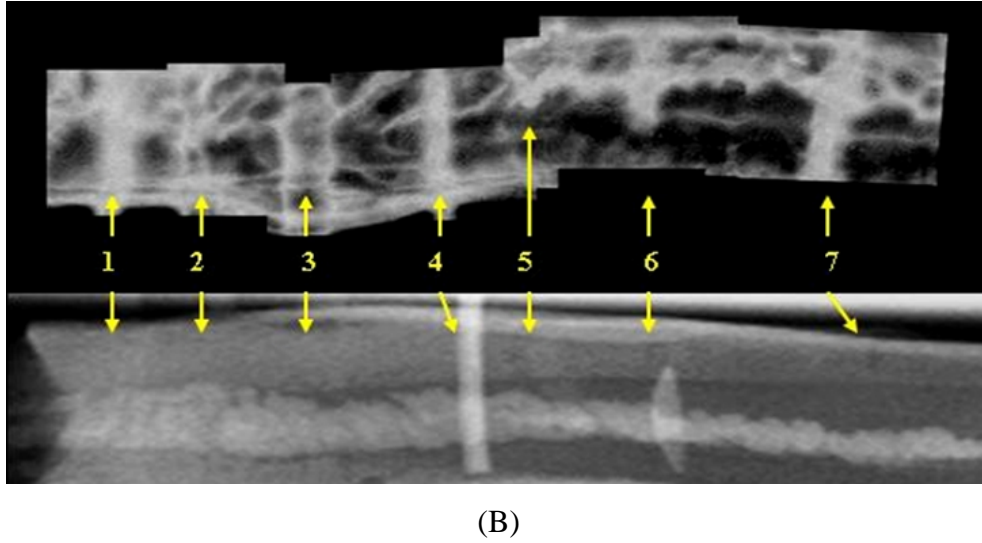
Displays of the inverted C-scan image with film-based radiograph and CR image: (A) C-scan image vs. film-based radiograph and (B) C-scan image vs. CR image. The numbers indicate the foreign objects corresponding to Table 5-1.
